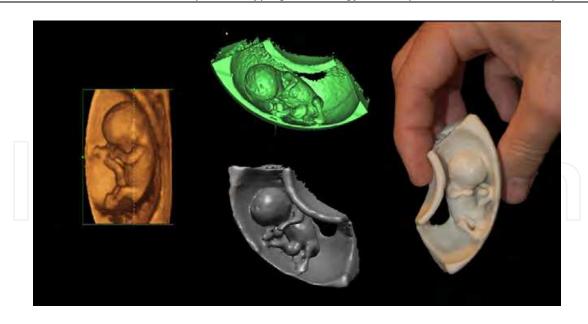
11 weeks virtual and physical model of fetus built on Z Corp 510 from Ultrasonography 3D files.
